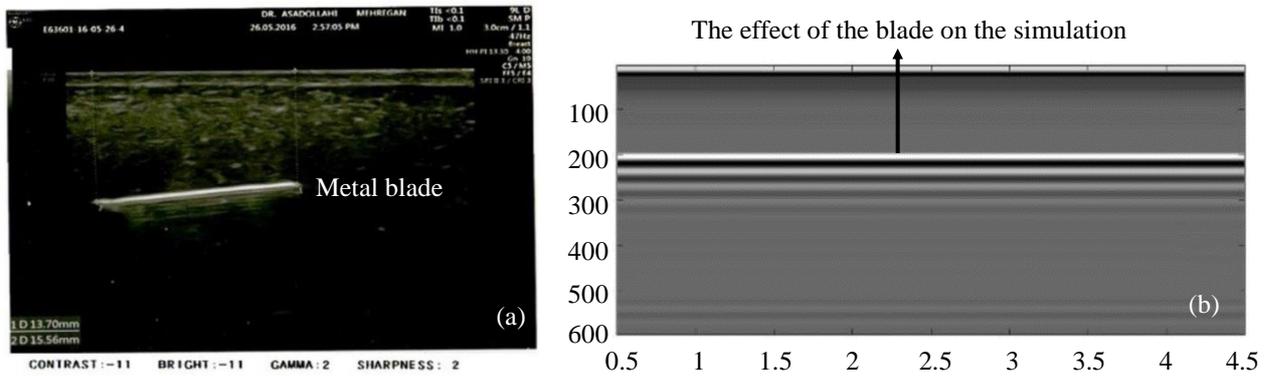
Display of the defect level: (a) In ultrasonic and (b) Combining received signals in A-Scan mode
